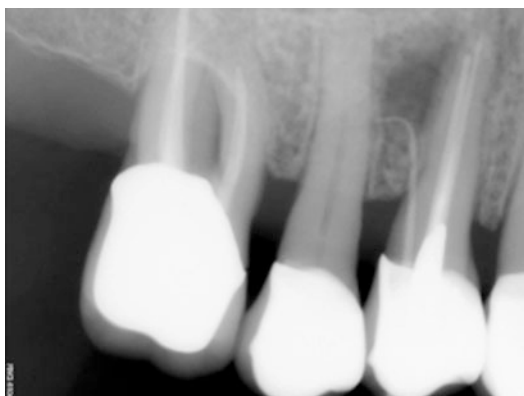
Radiograph (a) shows the initial radiograph taken upon diagnosis of no. 24; radiograph (b) was taken 6 months after showcasing significant healing of the surrounding bone around no. 25 (Radiograph courtesy of Dr. Joshua Yanover)
